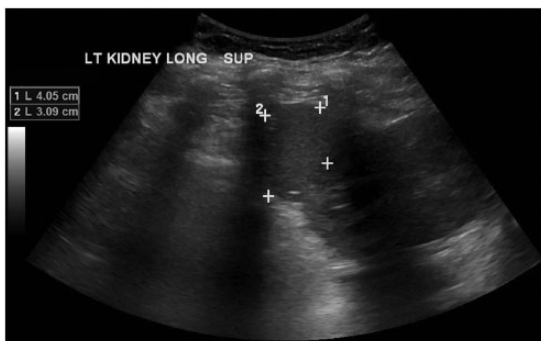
Grayscale ultrasound longitudinal image of the superior pole of the left kidney – a circumscribed homogeneous partially exophytic mass is demonstrated. The internal echogenicity of the mass resembles the sonographic appearance of splenic tissue. Note an absent spleen due to previous splenectomy.
